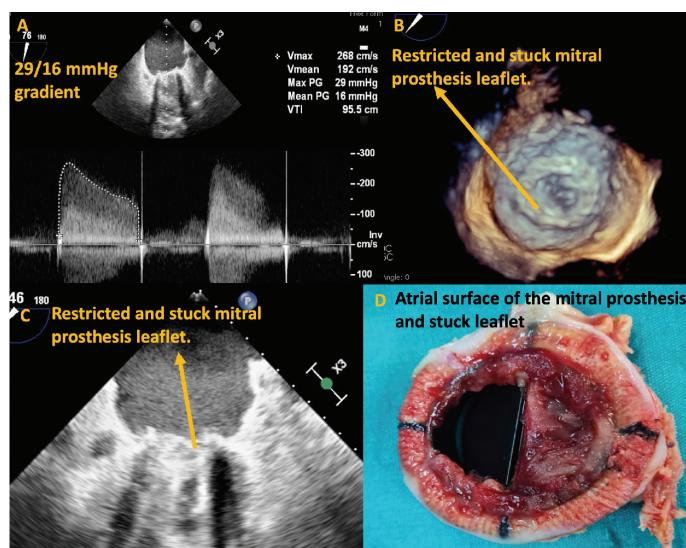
A-C; 2D and 3D transesophageal echocardiography images of increased mitral prosthetic heart valve gradient and restricted leaflet movements. D: Resected mitral prosthetic heart valve atrial surface images showed tissue overgrowth and stuck leaflets
